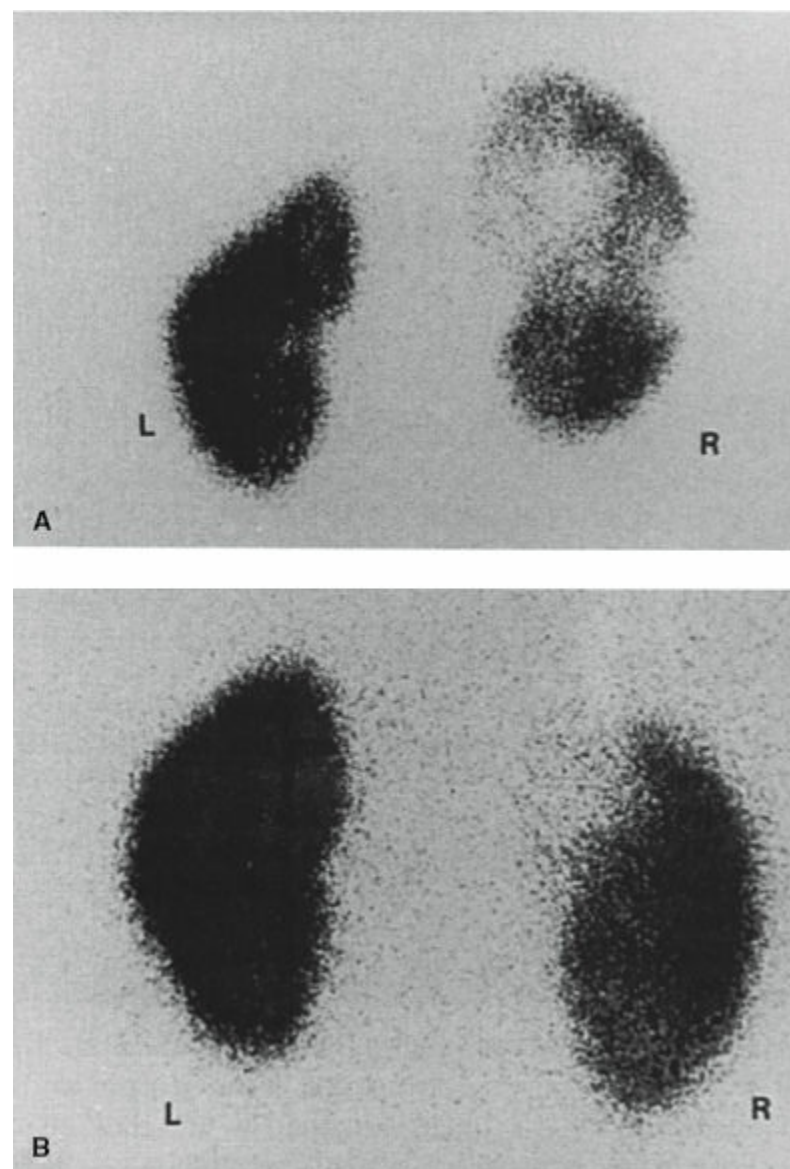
DMSA renal scintigraphy demonstrating renal parenchymal defect associated with pyelonephritis. A: Cortical defects seen in the right kidney during the acute phase of pyelonephritis. B: The same kidney 6 months later showing a persistent cortical scar involving the upper pole.
